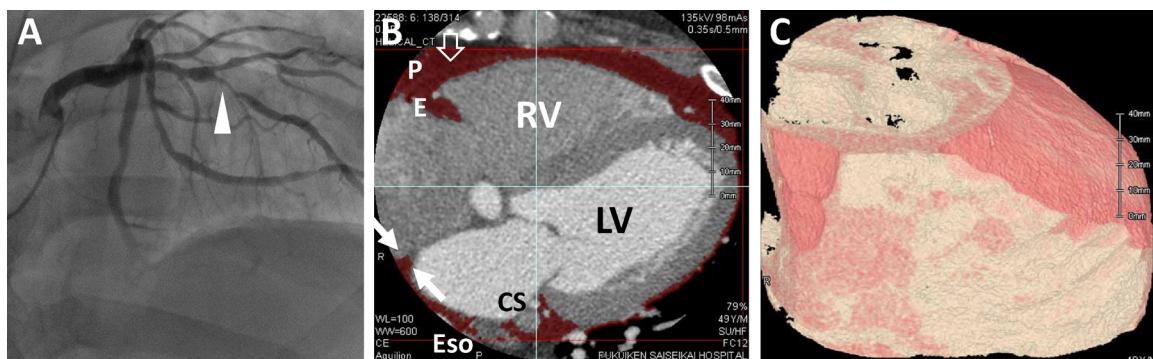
Representative case with high pericardial fat volume of a 49-year-old male with metabolic syndrome with a waist circumference of 106 cm. Invasive coronary angiography shows a significant stenosis at the middle segment of the left anterior descending coronary artery (A, arrow). Angiography with 64-multi detector computed tomography shows a large amount of pericardial fat (B). The parietal pericardium (open arrow), paracardial fat (P), epicardial fat (E), coronary sinus (CS), and esophagus (Eso) are visible. Solid arrows (B), fatty deposits within the atrial septum. And pericardial adipose tissue has been reconstructed three-dimensionally (C). RV, right ventricle; LV, left ventricle.
